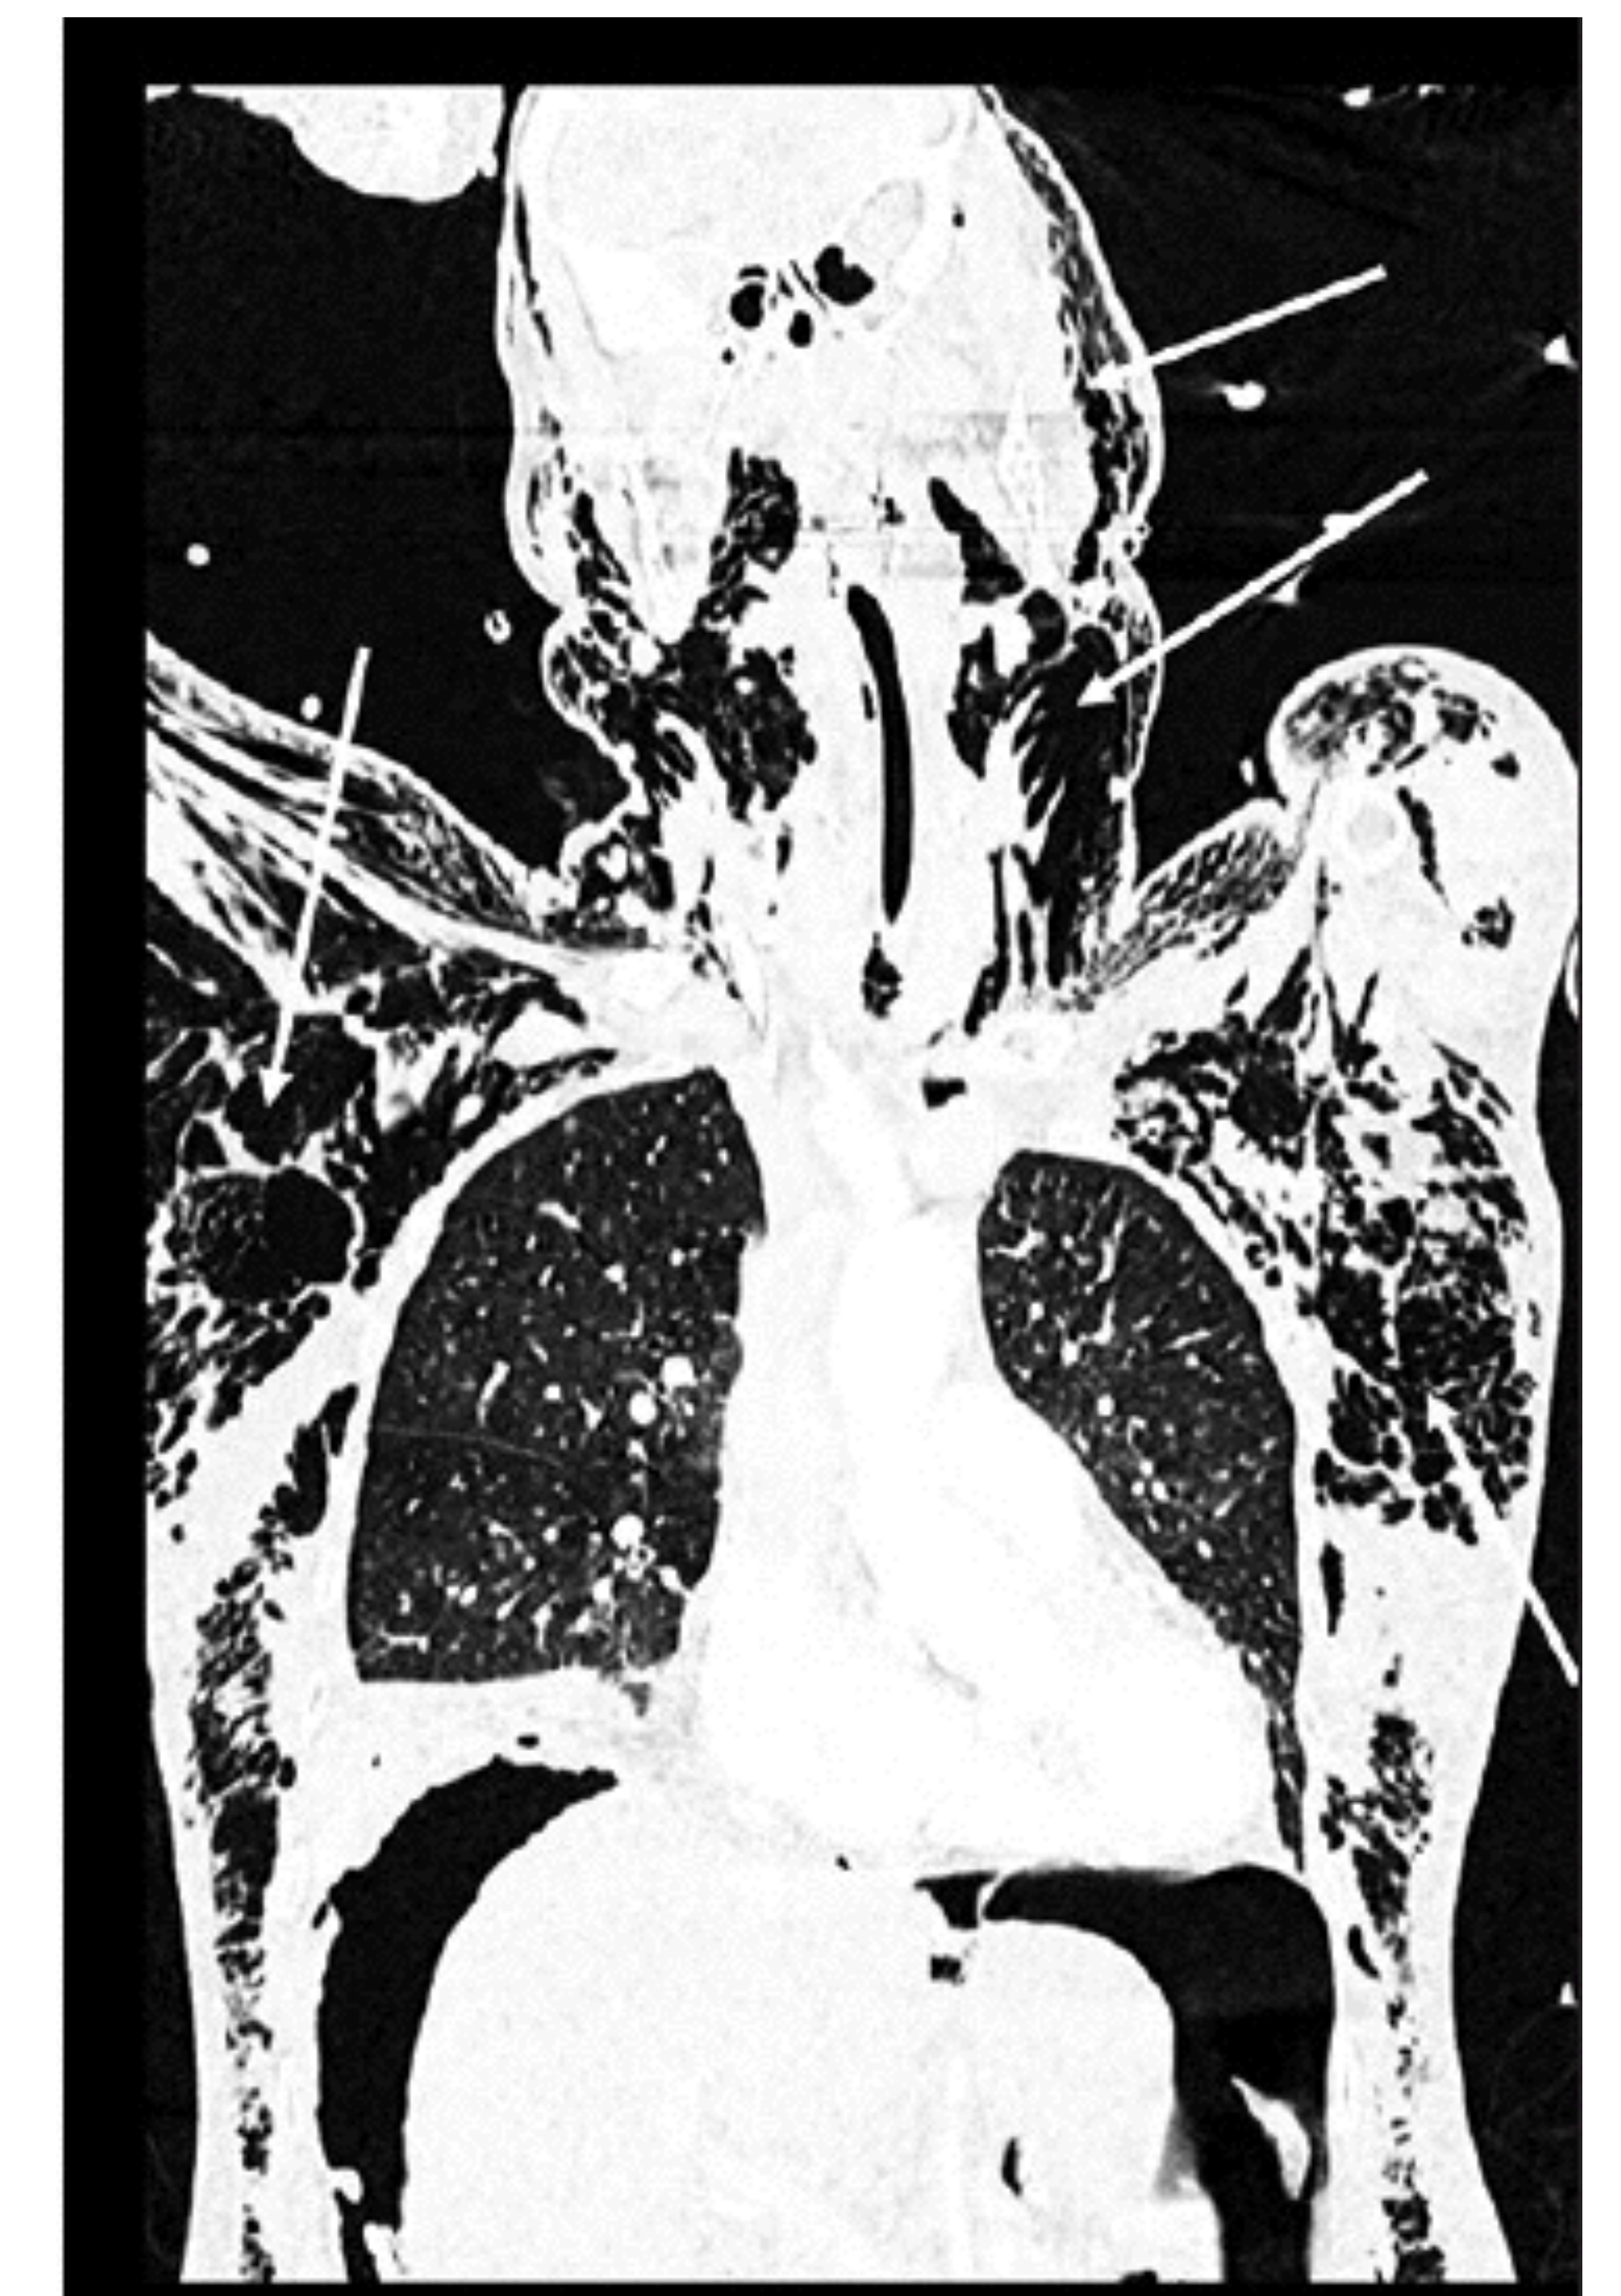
Reconstructed sagittal CT in bone window width. Demonstrating subcutaneous emphysema throughout thorax, neck and skull. (Diop et al., 2021, p. 107)
